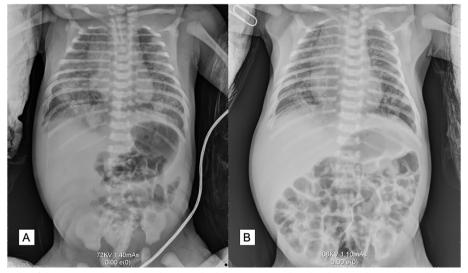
Chest radiographs of the neonate. The exudative lesions in both lungs improved 10 days later. A Chest radiograph on the first day after birth. B Chest radiograph on the 10 th day after birth
